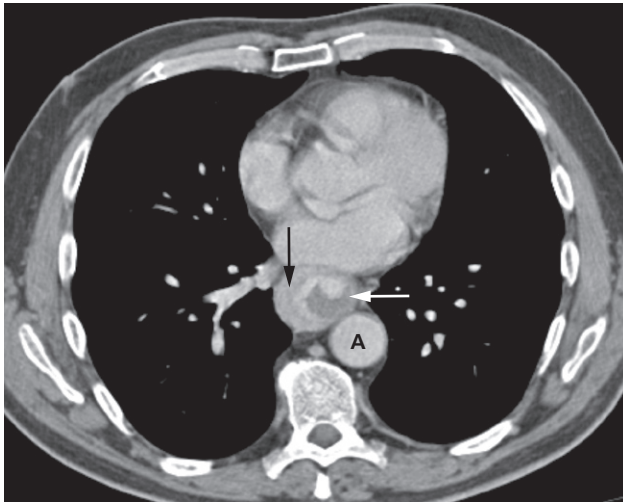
Oesophageal cancer on CT. There is thickening and enhancement of the right lateral oesophageal wall (black arrow). In this case, the left wall of the oesophagus is relatively normal (white arrow). A, aorta.
